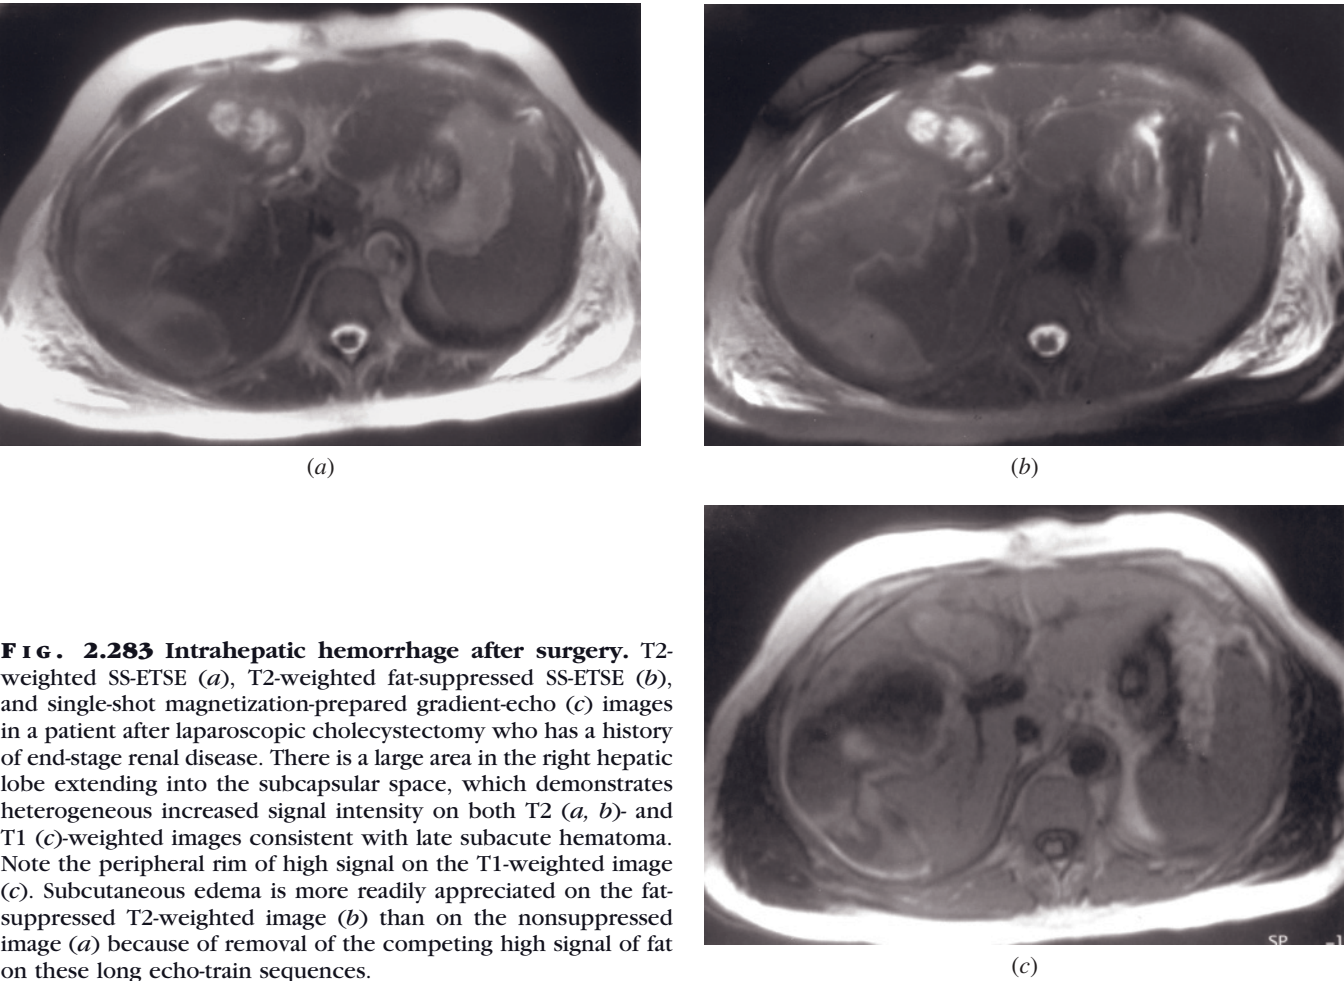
Intrahepatic hemorrhage after surgery. T2-weighted SS-ETSE (a), T2-weighted fat-suppressed SS-ETSE (b), and single-shot magnetization-prepared gradient-echo (c) images in a patient after laparoscopic cholecystectomy who has a history of end-stage renal disease. There is a large area in the right hepatic lobe extending into the subcapsular space, which demonstrates heterogeneous increased signal intensity on both T2 (a, b)- and T1 (c)-weighted images consistent with late subacute hematoma. Note the peripheral rim of high signal on the T1-weighted image (c). Subcutaneous edema is more readily appreciated on the fat-suppressed T2-weighted image (b) than on the nonsuppressed image (a) because of removal of the competing high signal of fat on these long echo-train sequences.
